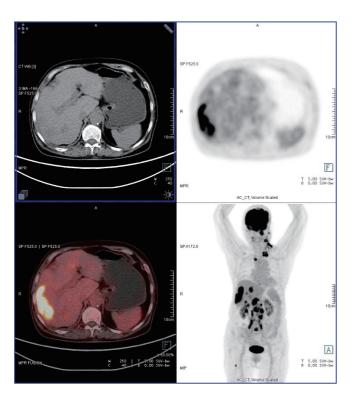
PET-CT. Multiple masses were detected in the liver, while the nasopharynx and lung were normal. Lymphatic Metastases were found in left cheek, left pharynx, bilateral neck, left supraclavicular area, right cardiodiaphragmatic angle, first hepatic hilum, abdominal periaorta, and bilateral common iliac periaorta. Skeletal metastases were also found in the right acromion, third thoracic vertebra, fifth lumbar vertebra, and right femur.
